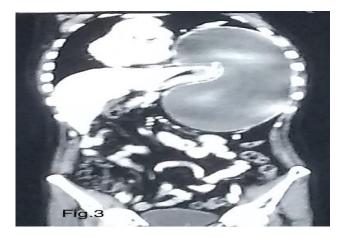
CT chest with abdomen, suggestive of defect in left hemidiaphragm with meso-axial rotation of stomach.
